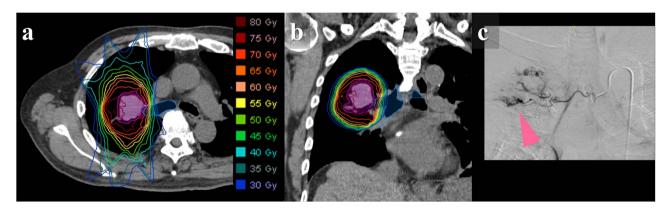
Imaging findings for a 75-year-old man with definite radiotherapy-related hemoptysis. (a) Axial and (b) coronal view of computed tomography (CT) images with the dose distribution of accelerated hypofractionated radiotherapy. (c) A radiograph at catheterization showing the source of bleeding in the right bronchial artery.
